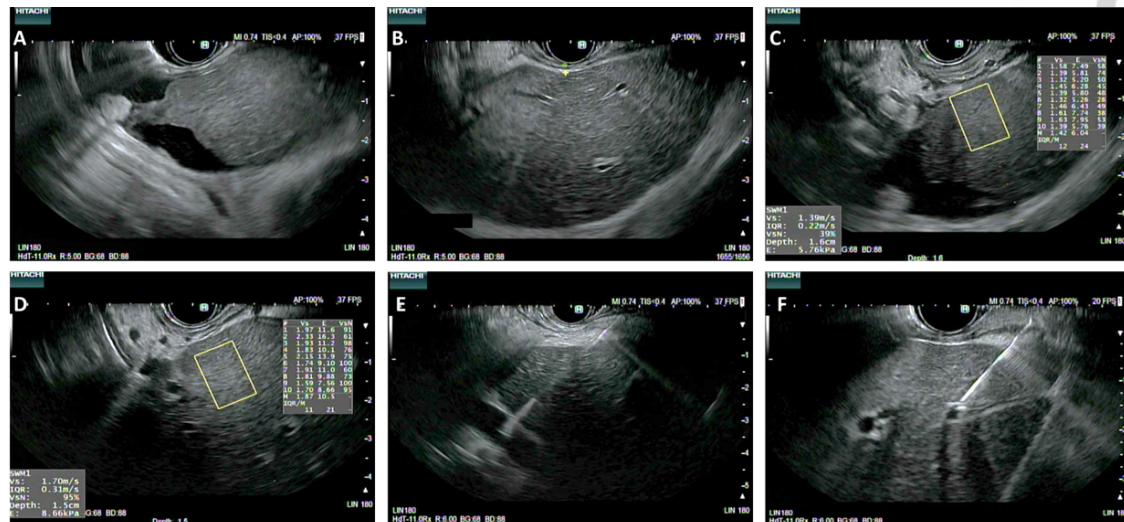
One-stop-shop endoscopic ultrasound (EUS) approach. A: EUS-liver observation suggestive of advanced chronic liver disease. B: Abnormal EUS-liver indentation. C: Normal left lobe shear-wave elastography. D: Abnormal left lobe shear-wave-elastography. E: EUS-guided portal pressure gradient (PPG) - portal vein. F: PPG measurement - left hepatic vein.
